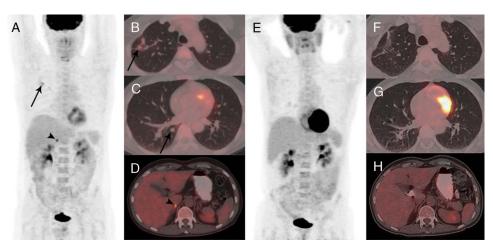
A 49-year-old man infected with the human immunodeficiency virus with a former history of tuberculosis presented with hemoptysis and thorax CT showed an irregular-shaped 1-cm pulmonary nodule in the right lung suspicious for malignancy. He was referred to FDG PET/CT to evaluate pulmonary nodule for malignancy. FDG PET/CT revealed mild FDG uptake in the nodular lesion in the apical segment of the upper lobe of right lung (arrows in A, MIP image; B, axial PET/CT image) and an ametabolic pulmonary nodule in the superior segment of the lower lobe of right lung (arrow in C, axial PET/CT image). Also, intense FDG uptake with an SUV_{max} of 7 was noted in the 1-cm nodular lesion in the right adrenal gland, suggestive of metastasis (arrowhead, D, axial PET/CT image). Wedge resection of the apical pulmonary nodule revealed necrotizing granulomatous inflammation, and microbiologic assessment showed Gomori methenamine silver-positive branching filamentous Nocardia spp. He received treatment for nocardiosis with trimethoprim/sulfamethoxazole, and a repeat FDG PET/CT showed complete regression of the adrenal lesion and pulmonary nodules (E, MIP image; F, G, H, axial PET/CT images). Nocardiosis is a rare, localized, or disseminated opportunistic infection caused by a Gram-positive, aerobic, filamentous bacteria, commonly affecting immunosuppressed patients, in whom it most commonly presents as pulmonary disease. Whole-body functional imaging with FDG PET/CT has an emerging role in the diagnosis of infection, identifying disease extent, defining the biopsy location, monitoring therapy response, and guiding therapy duration decisions for *Nocardia*. 1-Radiological features of pulmonary nocardiosis are nonspecific as it may present as consolidation, infiltration, solitary, or multiple nodules. 4 The clinical and radiological findings along with increased FDG uptake on PET scan may be misdiagnosed as malignancies.^{5,6} Also, in extrapulmonary nocardiosis, malignancy is often suspected in the setting of the abdominal or brain abscess, which can lead to misinterpretation as metastatic disease.⁷ Adrenal gland involvement in *Nocardia* infection is exceedingly rare and has been reported in a few case reports with immunocompetent and immunocompromised patients. 8-11 Adrenal abscess is usually confined to a single gland as a result of hematologic dissemination in disseminated nocardiosis patients or direct abdominal inoculation in peritoneal dialysis patients. 12 Despite its rarity in the clinical setting, this case hints us that nocardiosis may present with FDG-avid adrenal lesions, which could mimic metastatic disease, especially in patients with pulmonary nocardiosis.
